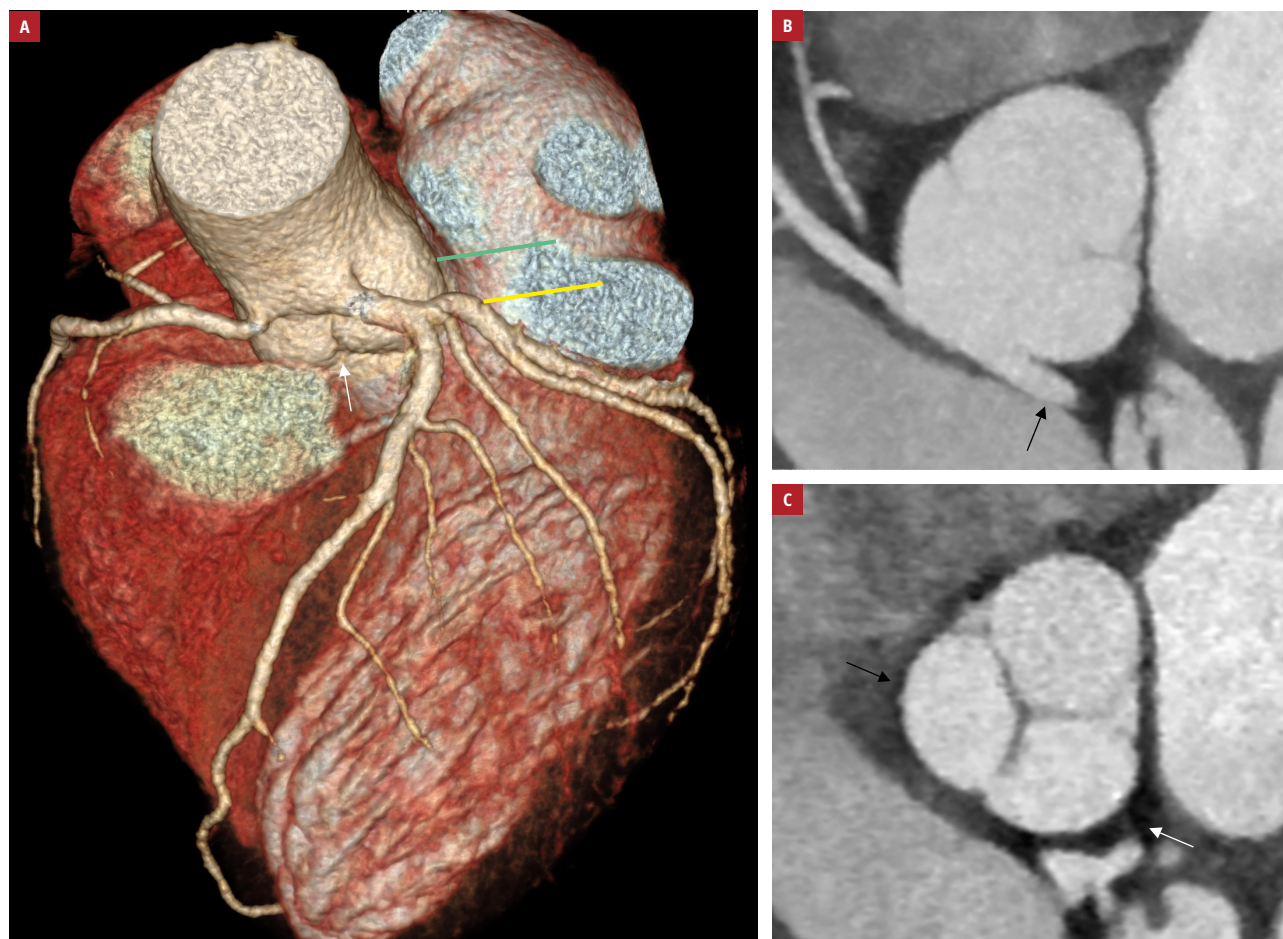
Computed tomography angiography: A – the left main coronary artery taking off above the commissure between the left and right coronary cusps (white arrow); B – cross-section of the sinus of Valsalva at the level of the coronary origins, corresponding to the green line from panel A. The black arrow indicates the left main coronary artery; C – cross-section of the sinus of Valsalva at the level of the coronary cusps, corresponding to the yellow line from panel A. The blue arrow indicates the right coronary cusp and the white arrow, the left coronary cusp.
